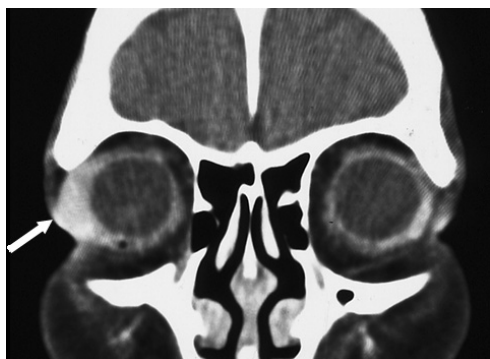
Lymphoid hyperplasia in a 43-year-old man. A contrast enhanced coronal CT scan shows a homogeneously enhancing elongated mass involving the right lacrimal gland (arrow).
